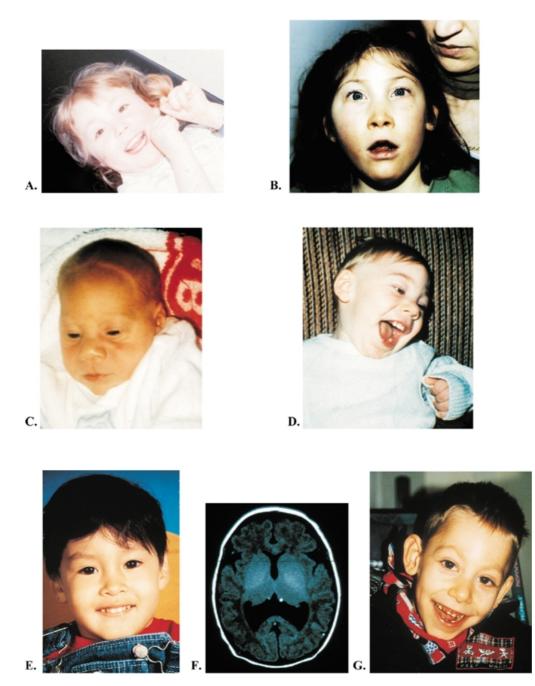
Facial photographs of HPE patients showing lack of severe facial malformations. (A) Patient 3; lobar HPE. (B) Patient 4; semi-lobar HPE. (C) Patient 7 at birth; semi-lobar HPE. (D) Patient 7 at 21 months. (E) Patient 9; middle interhemispheric fusion defect. (F) Patient 9; MRI showing middle interhemispheric fusion defect. (G) Patient 13; semi-lobar HPE.
